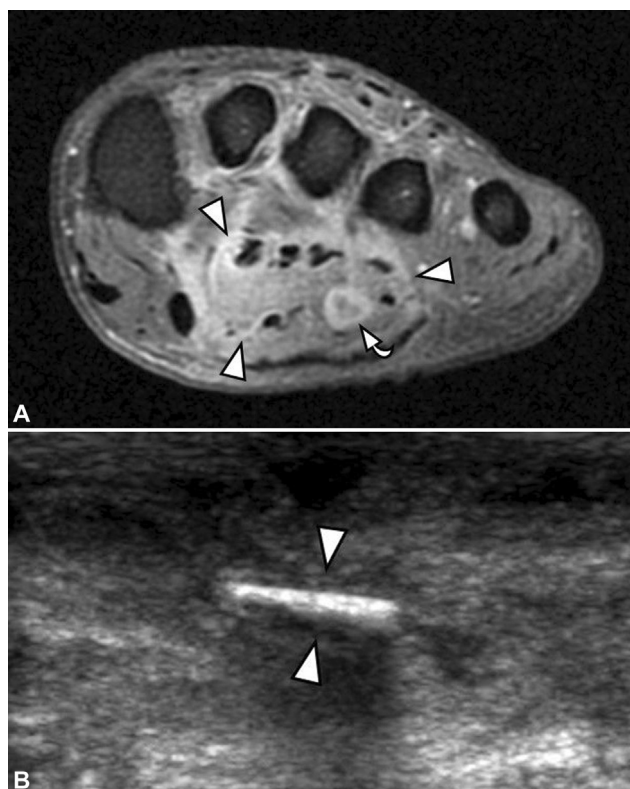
A 20-year-old man with foot pain after walking barefoot in woods 3 months prior. (A) Axial T1 postcontrast magnetic resonance (MR) image of the foot demonstrates swelling and enhancement of the plantar foot muscles (*arrowheads*) and a small rim enhancing abscess (*curved arrow*). (B) Ultrasound image demonstrates a linear echogenic focus (*arrows*) with posterior acoustic shadowing found to be a wood splinter at surgery. Radiographs often will not detect radiolucent foreign bodies made of wood or plastic.
